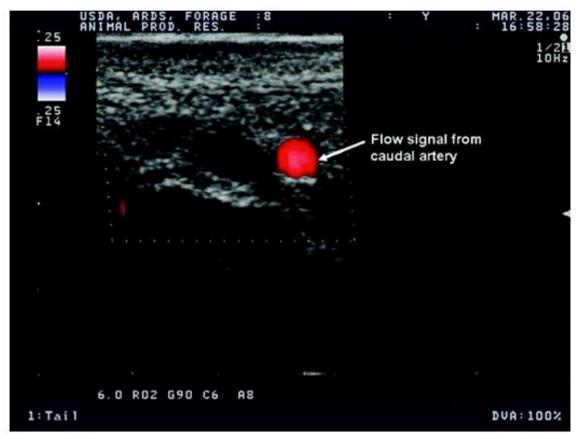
Ultrasound scan at a 2-cm depth of the cross-section of the caudal artery taken at the fourth coccygeal vertebra. Red Doppler flow signal delineates the area of flow through the artery (Aiken et al., 2007).
